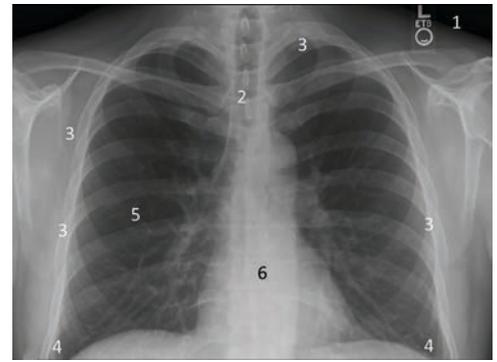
Steps for the chest x-ray (CXR) interpretation.
